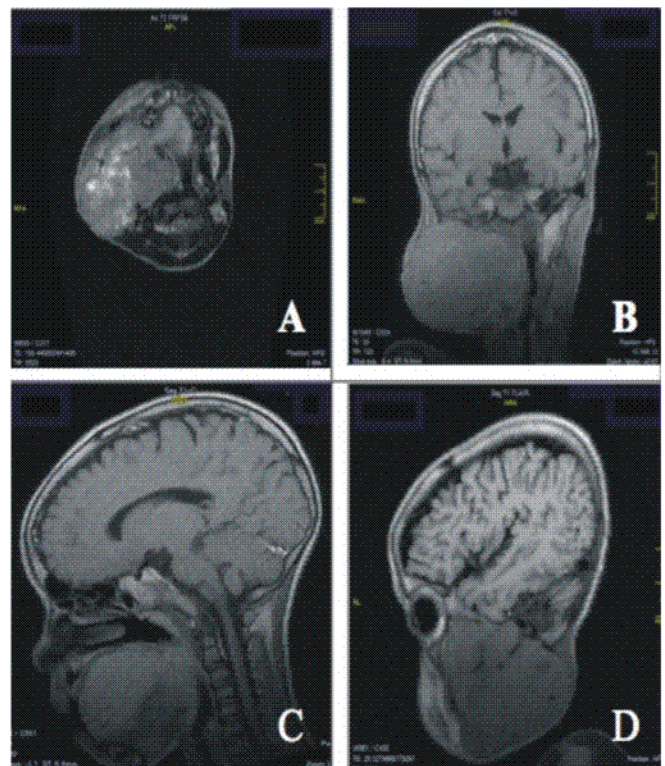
MRI showing: a dumbbell shaped expansile irregular mass in the parotid region (A&B). Appears extensive with extension into the oral cavity and upper margin of lesion in close proximity to the brain (C&D). Lesion is inhomogeneous hypo-intense on T1 Weighted image with foci of irregular more hypo-intensity. It is hyper-intensed on T2 Weighted image and enhances moderately with contrast.
